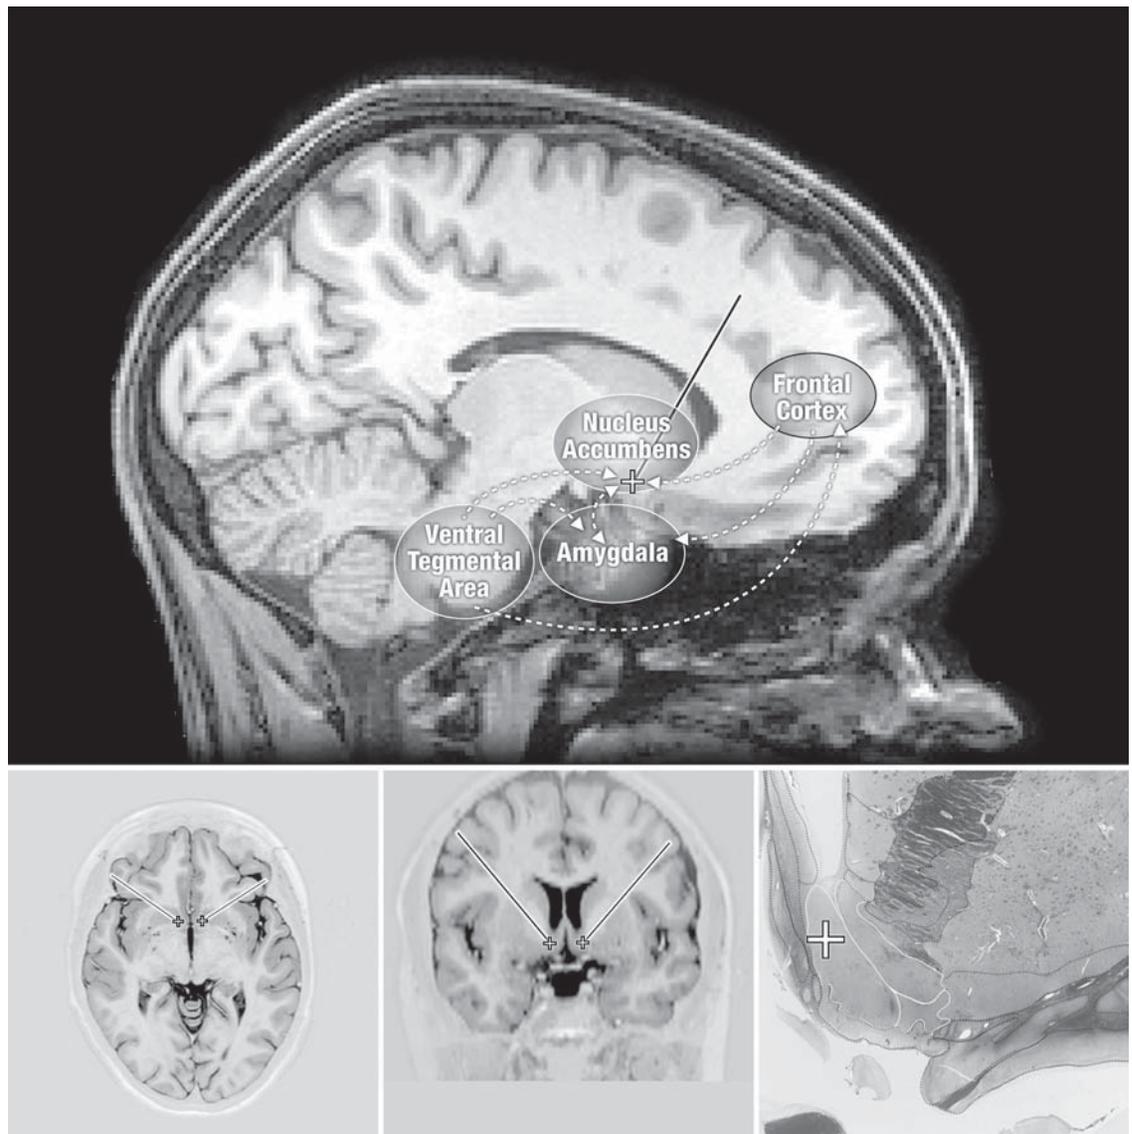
Reconstructed electrode trajectory superimposed on preoperative MRI. Graphic and anatomical presentation of the nucleus accumbens (cross) in different plains, extracted with permission from Mai et al. [11]. In addition the figure shows the main areas and pathways of the mesocorticolimbic circuit that are seen to be involved in chemical dependence.
